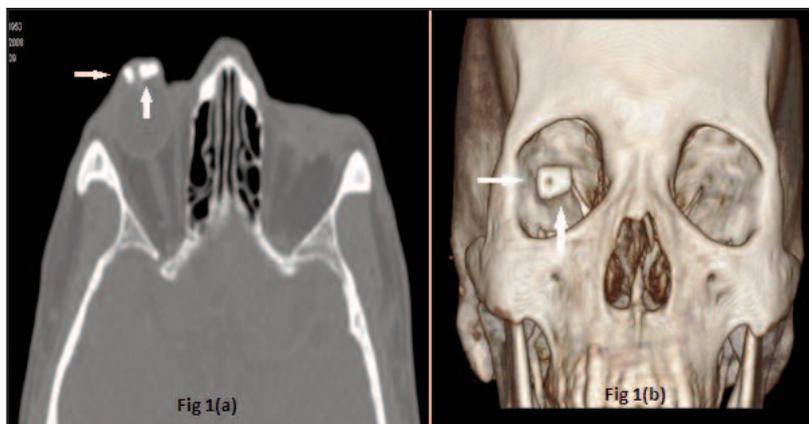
(a,b) :Non contrasted CT orbits in the axial projection (1a) and 3D reconstruction of the CT orbits (1b) showing the OOKP (⇒)
